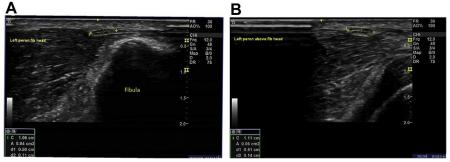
Ultrasound examination of a normal fibular nerve at (A) fibular head (nerve CSA 4 mm²) and (B) the knee (nerve CSA 6 mm²). (*Courtesy of* Katalin Scherer, MD.)
